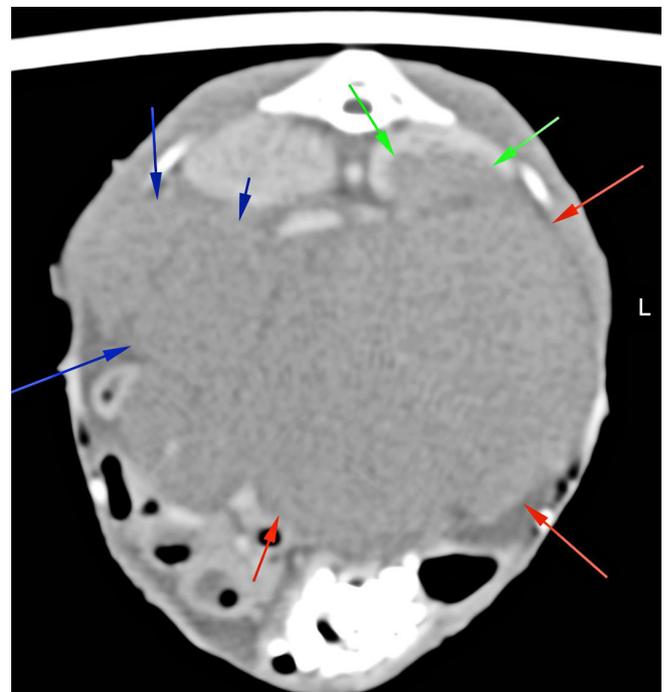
CT transverse plane through Case 2. Red arrows - large testicular tumour. Green arrows - infiltration of the tumour into the kidney. Blue arrows - tumour also in the right testicle. Compare to Figure 2.
